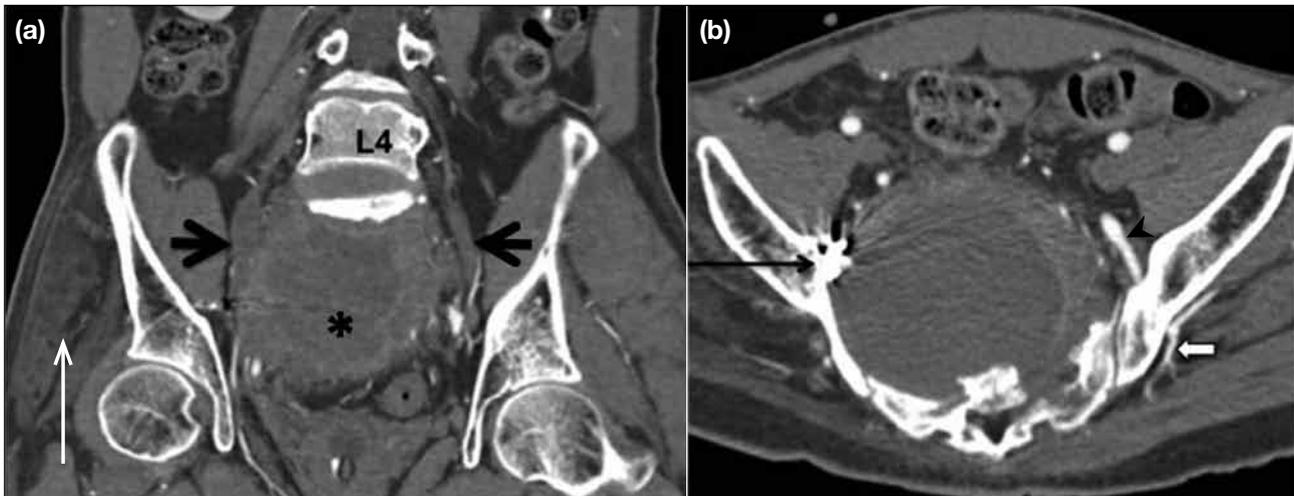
Computed tomographic angiography of the pelvis in the arterial phase. (a) The thrombosed pseudoaneurysm (asterisk) is contained by a thick fibrous layer and surrounding granulation tissues. Bilateral L4 spinal nerves swelling (horizontal black arrows) are evident, especially on the right due to compressive effect from the pseudoaneurysm. There is atrophy and fatty infiltration of the right gluteal muscles (vertical white arrow). (b) There is erosion of the sacrum, neural foramina and right sacro-iliac joint. Embolic material (black arrow) located at the right lateral aspect of the pseudoaneurysm is visible. Normal posterior trunk of the left internal iliac artery (arrowhead) and superior gluteal artery (white arrow) are well-depicted. Non-opacification of the right superior gluteal artery represents arterial disruption at the site of pseudoaneurysm.
